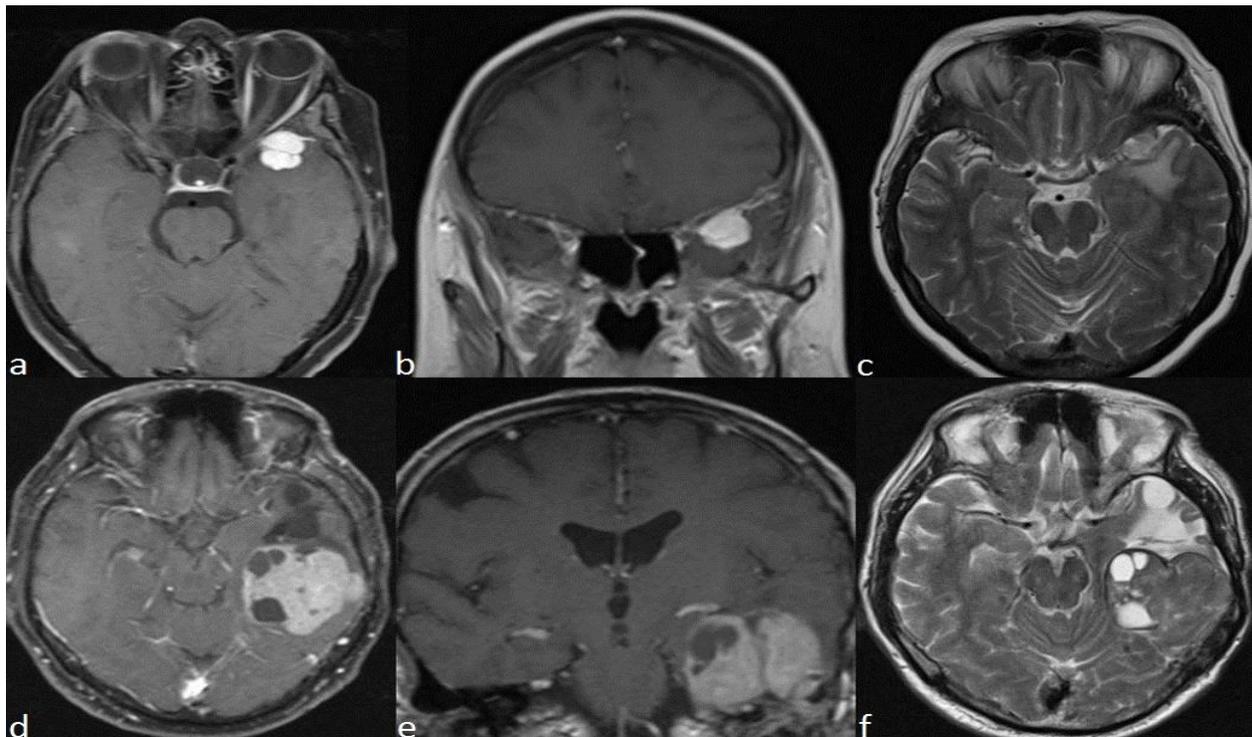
A left temporal Grade 1 secretory meningioma presenting with seizure shows homogeneous contrast enhancement (a and b) and PTE on T2 weighted (c) MR images. A Grade 1 fibrous meningioma which also shows contrast enhancement with cyst formation (d and e) and PTE on T2 weighted images (f) without preoperative epileptic seizure. PTE: peritumoral edema.
